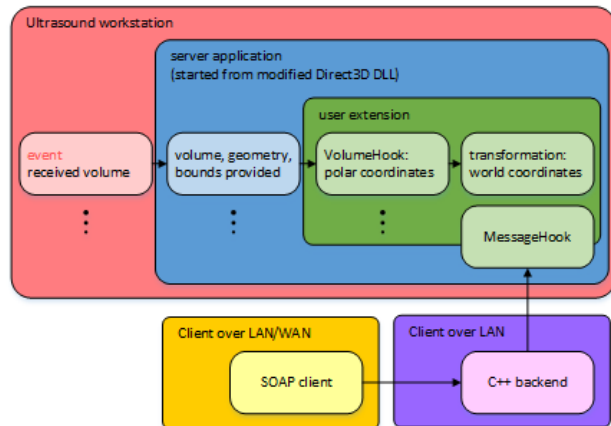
Ultrasound volume pathway from workstation to client applications.
